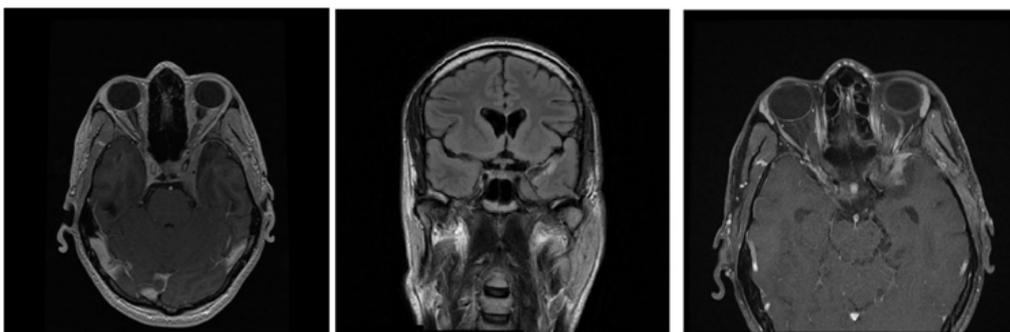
T-lymphoma MRI images.
